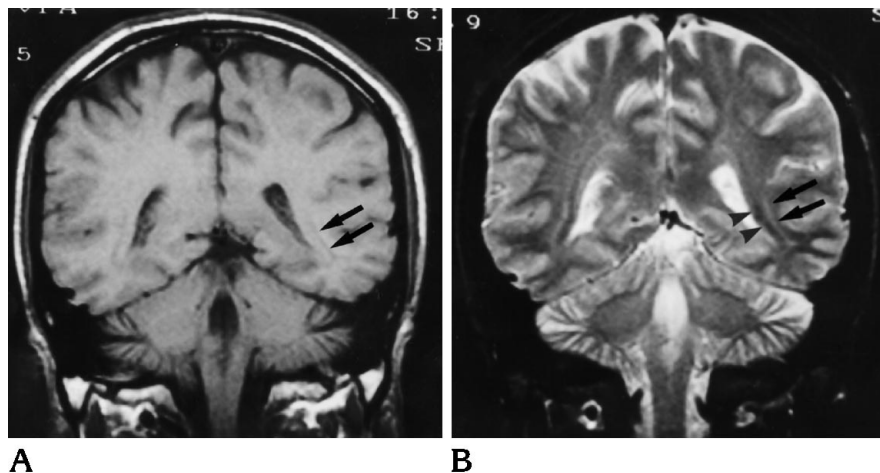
Coronal MR images from a healthy volunteer.
